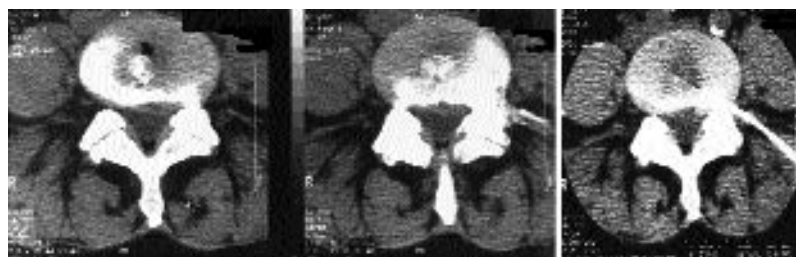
Left:* Preoperative computerized tomography (CT) scans revealing asymmetrical disc protrusion extending to the left lateral recess at L4–5 that was associated with both L-4 and L-5 radiculopathy. *Right:* Immediate postoperative CT scan indicating the proper position of the Hemovac tube in the path of the previously inserted cannula, which was used for annular resection and subcapsular decompression of the paramedial disc protrusion. Note that the Hounsfield number at the site of protrusion (2) is reduced to 1.0. The Hounsfield number on the annulus, away from the surgical site (1), is 76.3 and the dural sac (3) is 4.3.
